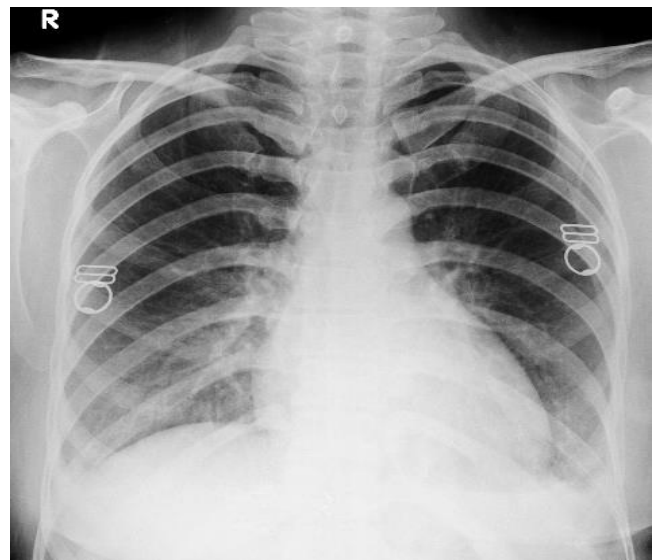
Almost normal chest radiography after treatment
